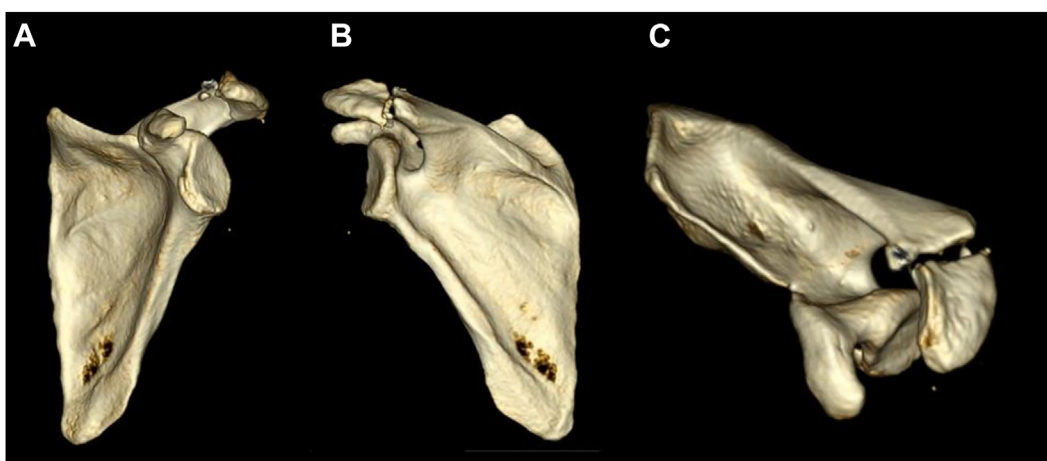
CT 3D reconstruction demonstrating (A) bony Bankart lesion and (B and C) displaced acromion fracture.
